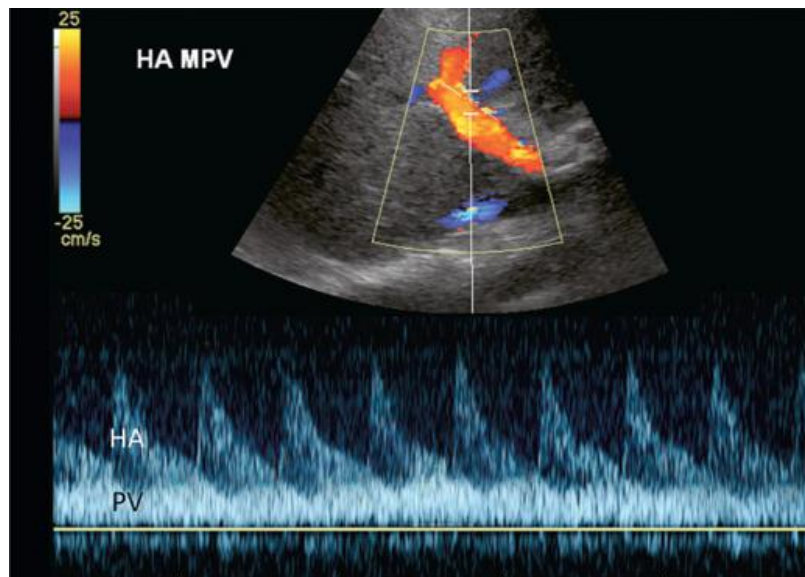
Spectral Doppler tracing of normal portal vein and hepatic artery flow. Slight periodicity is present in this patient's portal vein tracing. The dip in antegrade velocity coincides with hepatic arterial systole. The comparison of the two flow profiles is achieved by interrogating with a wide sample volume that encompasses both the artery and the vein in one tracing. Velocity variation may also occur due to pressure change with the hepatic vein A-wave but those
